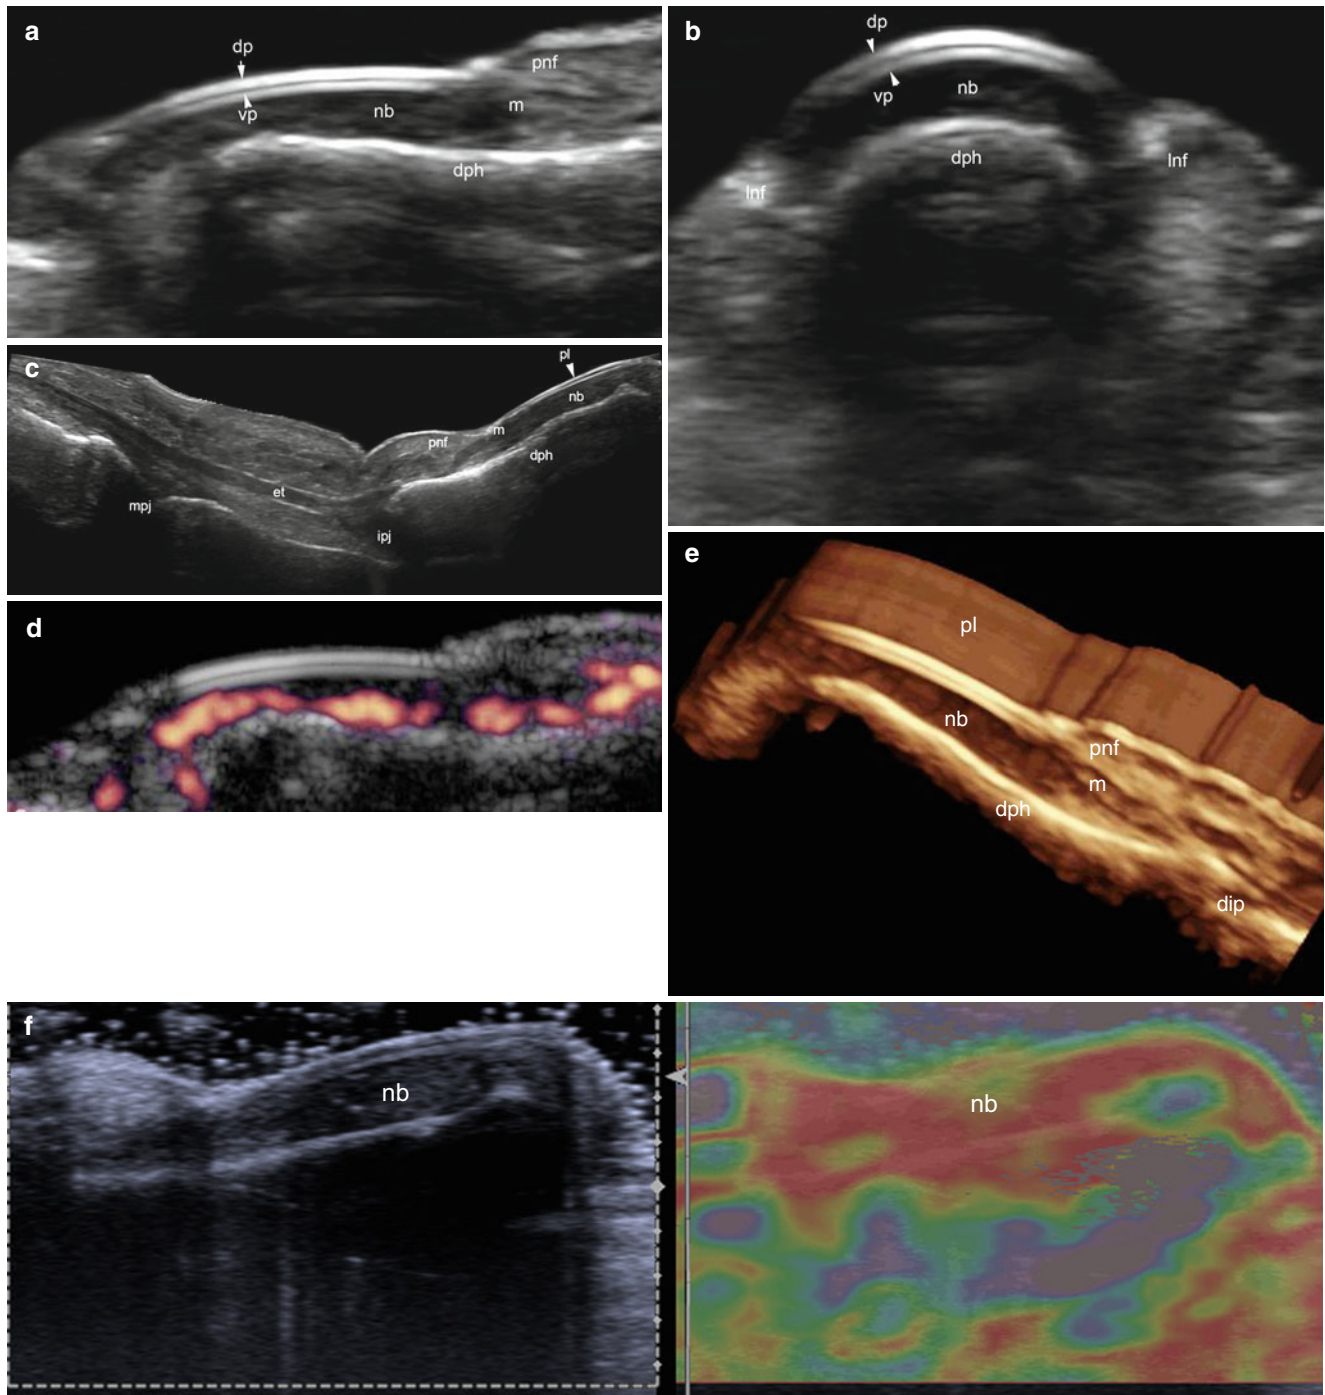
(a–f) Sonographic anatomy of the nail. (a–c) Grey scale ultrasound images (a longitudinal view; b transverse view; c extended field of longitudinal view) show the different parts of the nail unit. (d) Power Doppler ultrasound image (longitudinal view) shows the normal blood flow within the nail bed. (e) 3D reconstruction of the nail (5–8 s sweep) highlights the different components of the nail unit. (f)
